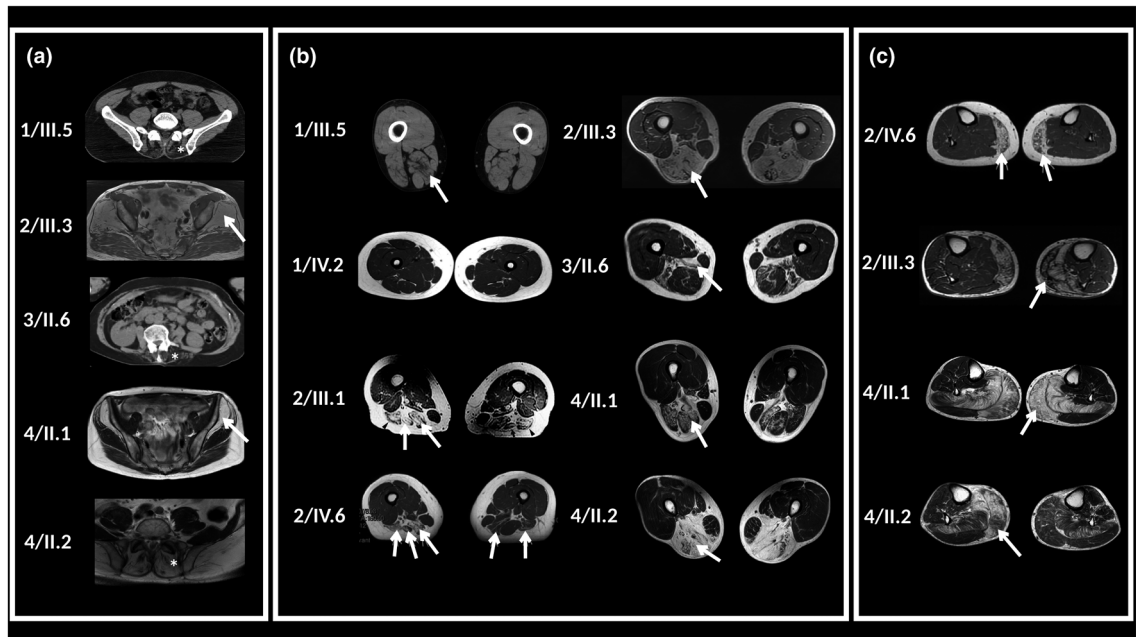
Muscle imaging findings in eight patients harbouring the c.1333G>A *CAPN3* variant. CT muscle imaging was performed in patients 1/III.5 and 3/II.6 and muscle MRI was performed in patients 1/IV.2, 2/III.1, 2/III.3, 2/IV.6, 4/II.1, 4/II.2. Patients numbers are indicated in this figure and correspond to those indicated in the family trees in Figure 1. (A) CT and MRI imaging of lumbar and pelvic muscles of five patients. Patients 1/III.5, 3/II.6 and 4/II.2 have severe fatty replacement of lumbar paraspinal muscles (asterisk). Patients 2/III.3 and 4/II.1 have heavy fibro-fatty bilateral changes in glutei minimi and medii muscles (arrows) with respect of gluteus maximus. (B) CT and MRI imaging of thighs of eight patients. CT muscle scan of patient 1/III.5 shows selective hypodensities in semitendinosus and semimembranosus more pronounced on the right side (arrow). Axial imaging (T1 sequences) of patient 1/IV.2 at 8 years, shows no involvement of thighs muscles. MRI imaging (T1 sequences) of patient 2/III.1, 2/III.3 and 4/II.2 shows severe fatty degenerative changes in hamstrings on both sides with preservation of sartorius and gracilis muscles. Patient 2/IV.6 fatty degenerative changes are present in the hamstrings predominantly on the right side, bilaterally in semimembranosus and long head of biceps femoris and in semitendinosus also on the right side. In T1 axial slice of patient 3/II.6, selective hypodensities are present in hamstring muscles, mainly on the left side. Biceps femoris and adductor magnus are the most seriously affected by fatty infiltration. (C) CT and MRI imaging of legs of four patients. On T1 axial slices of both lower legs of patients 2/III.3, 2/IV.6, 4/II.1, 4/II.2, fatty degenerative changes were present at the posterior compartment of legs, mainly in gastrocnemius medialis (arrows). On muscle imaging of the other four patients, legs muscles were unaffected (data not shown). In patient 2/III.3, there was a significant muscle atrophy of the posterior compartment on the left side. In patients 4/II.1 and 4/II.2, fatty degeneration on gastrocnemius medialis and soleus muscles is pronounced, whereas gastrocnemius lateralis is relatively spared.
